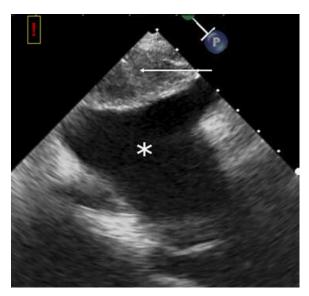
Mediastinal hematoma (arrow) compressing left atrium (white asterisk) on intraoperative transesophageal echocardiogram.
